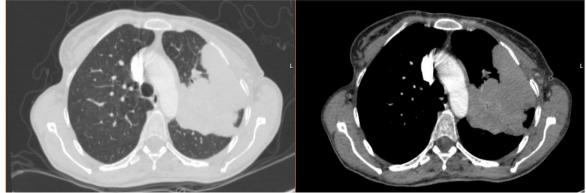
Thorax CT revealed 13 cm size lung mass with thoracic wall invasion
